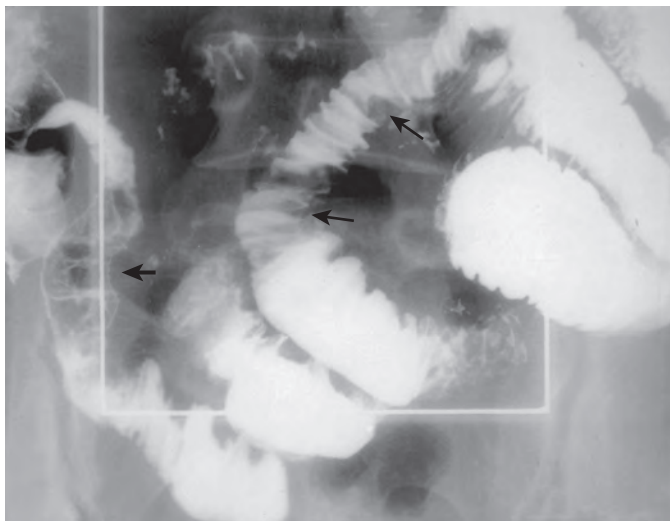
Eosinophilic enteritis. This spot radiograph from a small bowel follow-through shows thickened, straight folds (small arrows) in several loops of distal small bowel and an abnormal surface pattern (thick arrow) in the terminal ileum.
